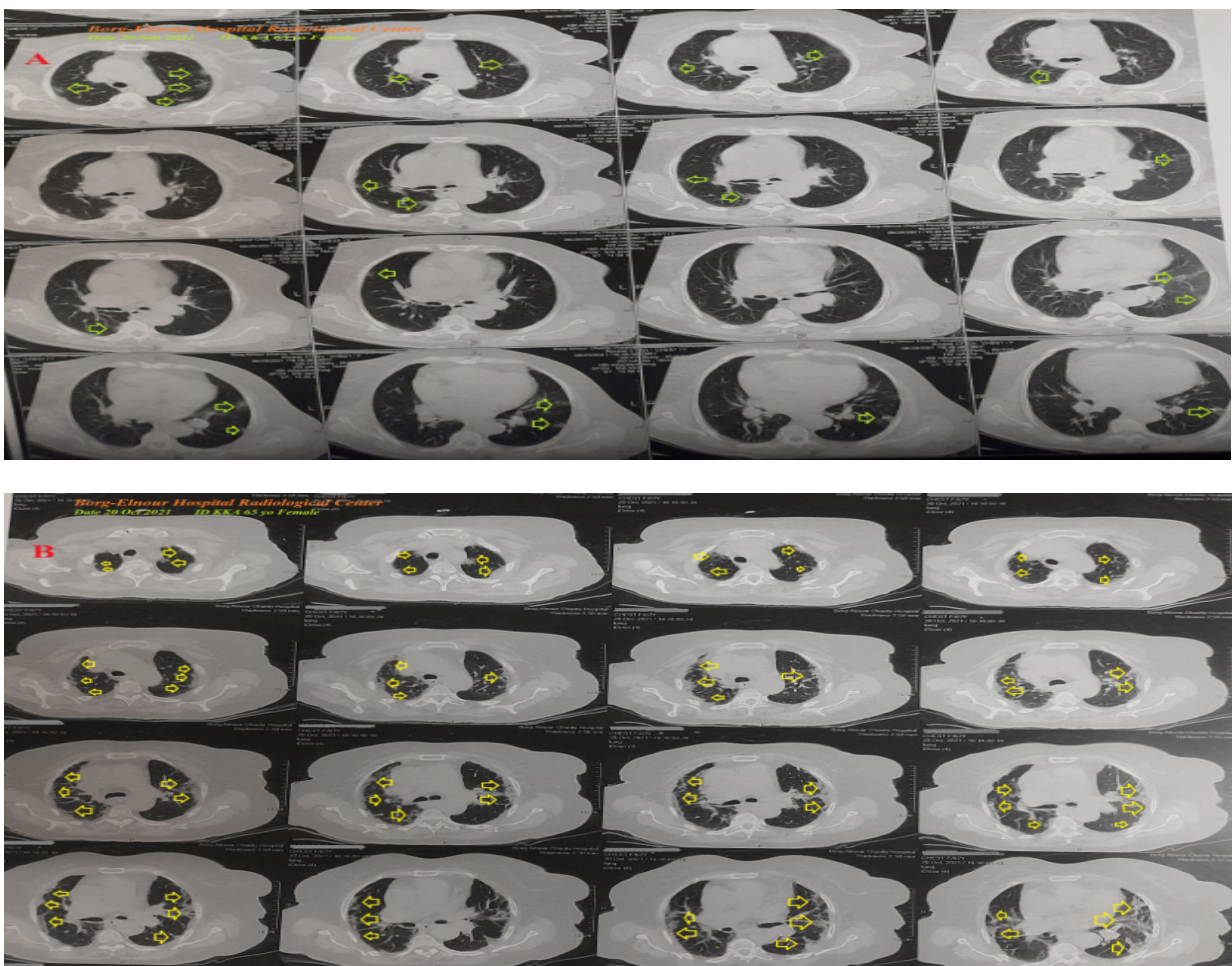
(A). Chest CT without contrast was done on the initial presentation showing mild bilateral small-sized ground-glass opacities (lime arrows). (B). Chest CT without contrast was done on the hospital discharge showing previously severe bilateral vague hazy variable-sized in healing ground-glass opacities (yellow arrows).
